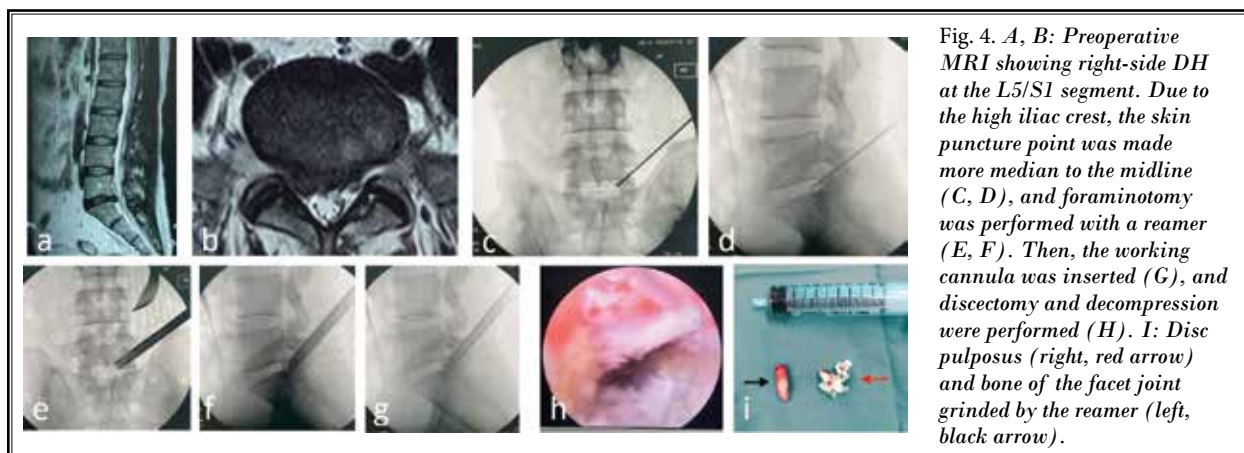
A, B: Preoperative MRI showing right-side DH at the L5/S1 segment. Due to the high iliac crest, the skin puncture point was made more median to the midline (C, D), and foraminotomy was performed with a reamer (E, F). Then, the working cannula was inserted (G), and discectomy and decompression were performed (H). I: Disc pulposus (right, red arrow) and bone of the facet joint grinded by the reamer (left, black arrow).
